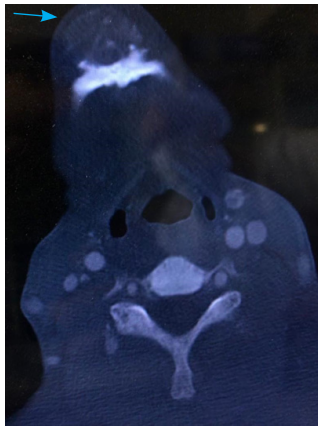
An axial computed tomography scan showed a mass lesion of the mandible (blue arrow).
